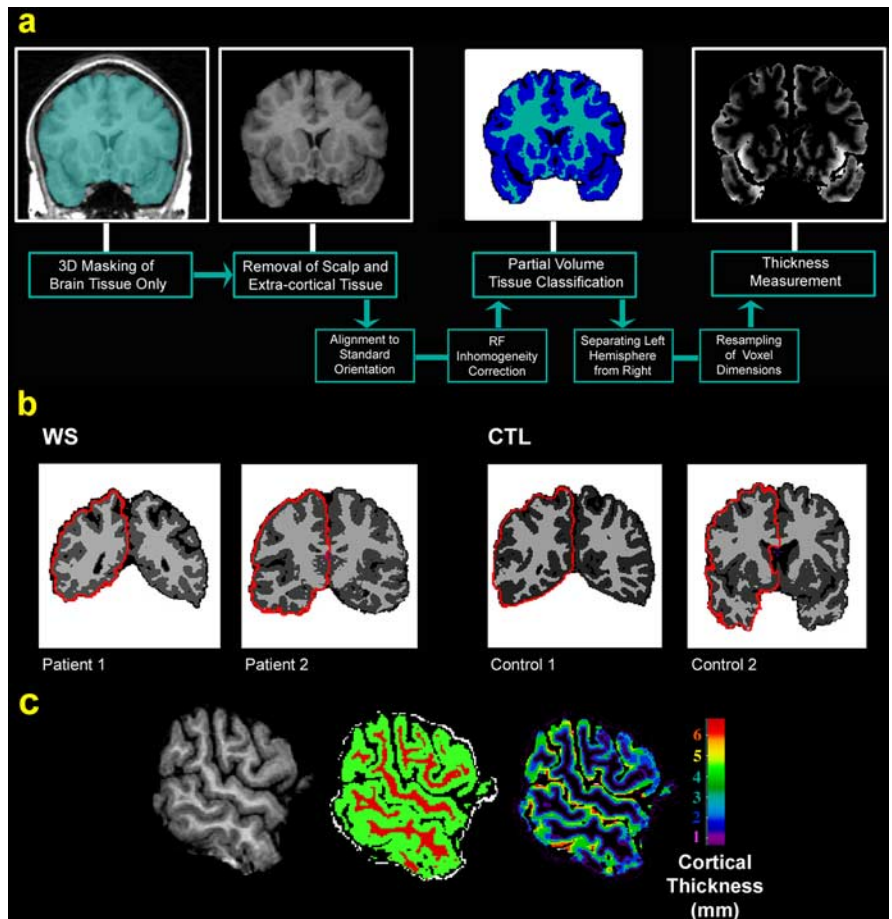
Steps used to create cortical thickness maps. *a*, Sequence of steps required to derive cortical thickness maps from the MRI scans (for details, see Materials and Methods). *b*, Representative coronal sections from the gray and white matter maps in two WS patients and two healthy controls. The extraction of a smoothed outer cortical surface is also shown in red. *b*, *c*, A sagittal cut from the original T1-weighted image for one representative control subject, their tissue-segmented image (*b*), and their gray matter-thickness image (*c*), in which thickness is progressively coded in millimeters from inner to outer layers of cortex using a distance field. CTL, Control; RF, radio frequency.
